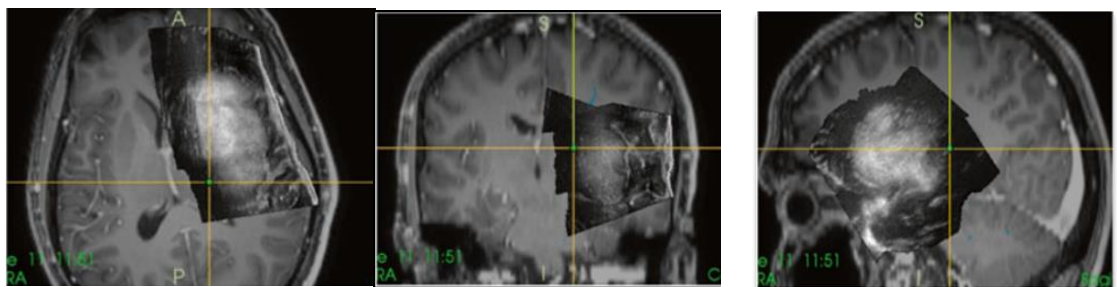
Real-time B-mode images superimposed on preoperative MRI to ease the surgeon's image interpretation [19].
